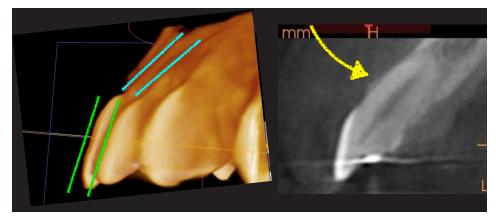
Debond Records: very nice control of axial inclination, the CBCT demonstrates the presence buccal plate
